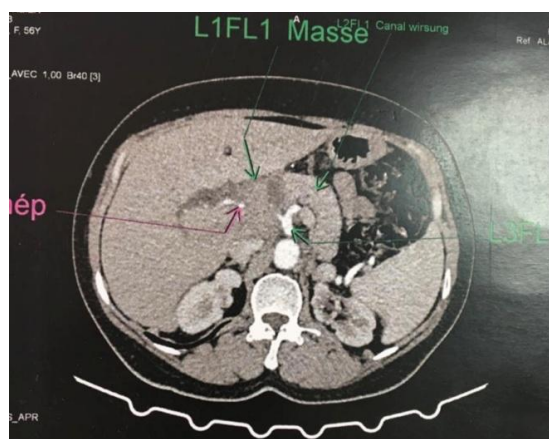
Abdominal CT scan showing a mass in the pancreatic head
